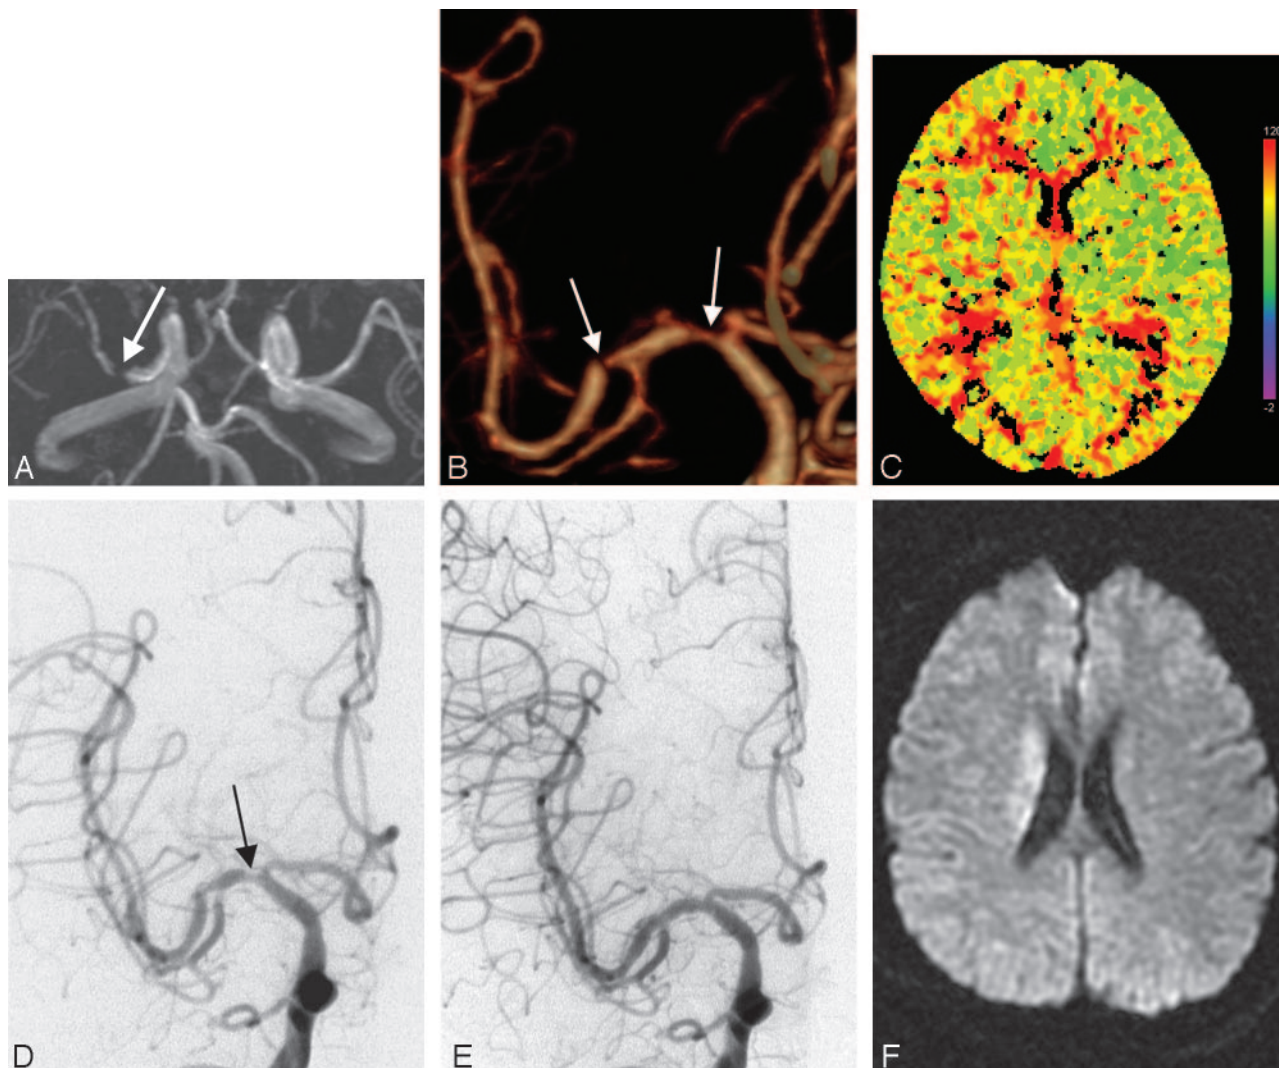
A 45-year-old male presented after multiple TIAs. Adjacent tandem lesions of the right MCA, are revealed by the arrows in A and B. A, The initial MRA showed a severe stenosis of right M1 (arrow in A) and failed to demonstrate an adjacent distal tandem lesion because of the decreased signal intensities distal to the first stenotic lesion. B, The oblique CT angiogram shows both severe tandem lesions (arrows) with more than 70% stenosis. C, There was an increased time-to-peak delay on CT perfusion image in the right MCA territory. D, The M1 lesion did not seem to be severe (arrow) on the anteroposterior view of cerebral angiogram due to the marked eccentricity of the M1 lesions. E, Final angiogram after concomitant stenting revealed good patency of the right M1 and improved angiographic flow into the right MCA territory. F, Diffusion-weighted MR imaging performed 2 days later, revealed acute ischemic change in the right caudate nucleus. The newly developed mild extremity weakness (minor stroke) eventually disappeared completely. There was no evidence of restenosis on TCD at 7 months and no symptomatic recurrence during the 17-month follow-up.
